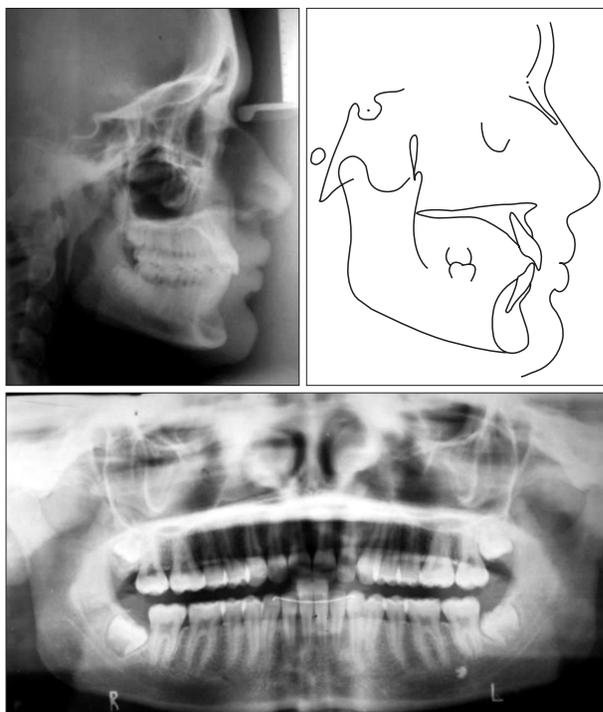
Posttreatment panoramic and cephalometric radiographs and tracing.
